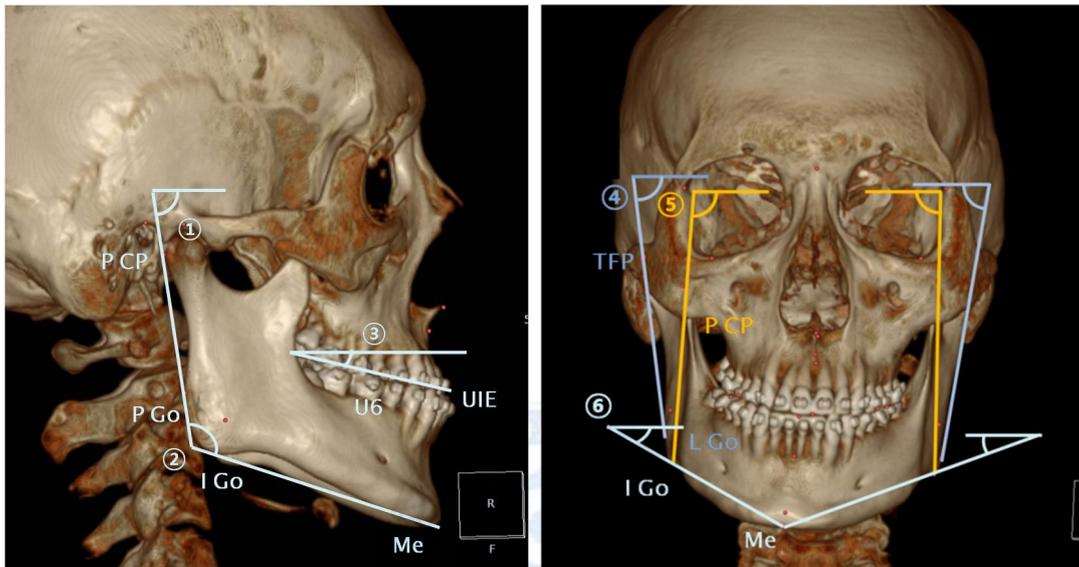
Angular measurements in 3D CT
